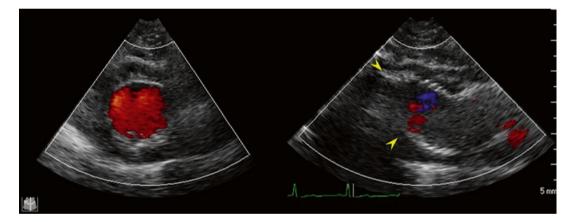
2D TEE color Doppler of descending aorta, x-plane view, status post aortic reconstruction, showed flow within the artificial graft (*arrows*)
